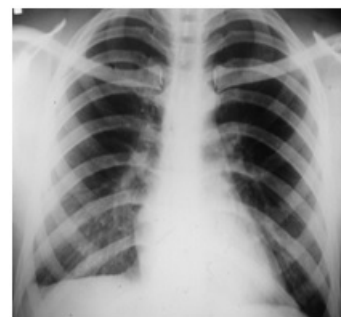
Chest x-ray at admission to ER
